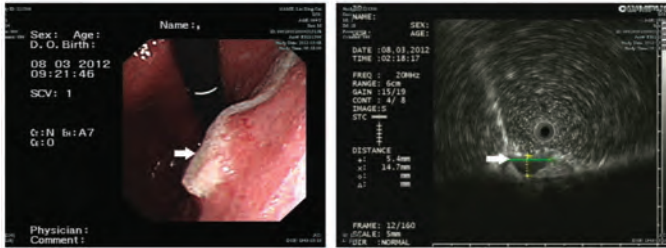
Ultrasonic endoscopy shows a submucosal lesion with an active ulcer on the mucosal surface (arrow). The lesion is approximately 1.47×0.54 cm.
